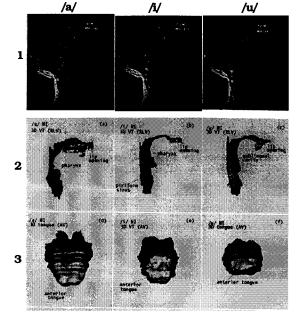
MRI data for vowels /a,i,u/ of a male subject (MI). (1) Mid-sagittal images (2) 3D vocal tract images, lip opening toward the right of each panel (3) Anterior view of 3D tongue shapes, tongue tip toward the bottom of each panel.
